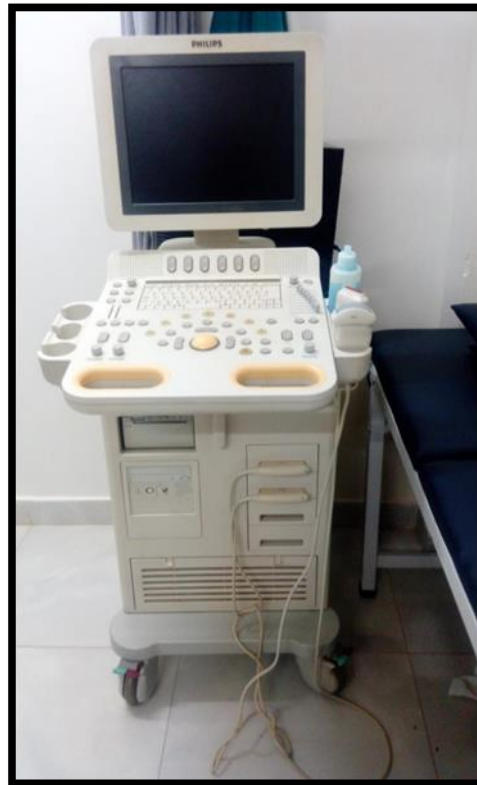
Philips HD7 ultrasound machine
